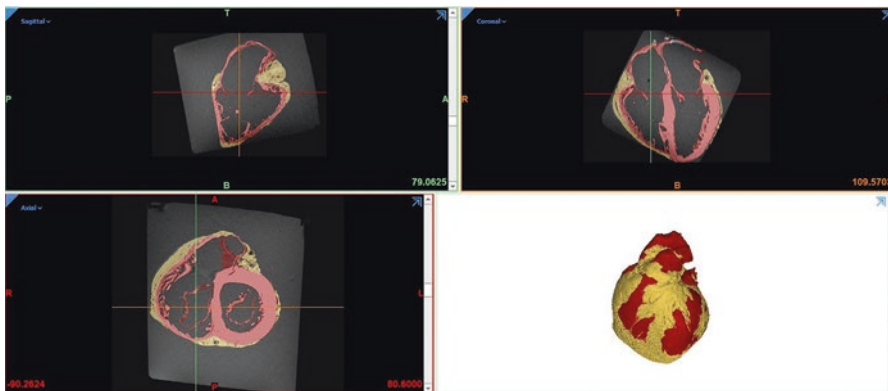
Heart segmentation from an *ex vivo* cardiac MRI. Segmentation labels superimposed onto the MRI image in the (a) sagittal, (b) axial, and (c) coronal view. (d) Volume rendering of the segmented heart. Muscle tissue can be seen in red and fat in yellow
